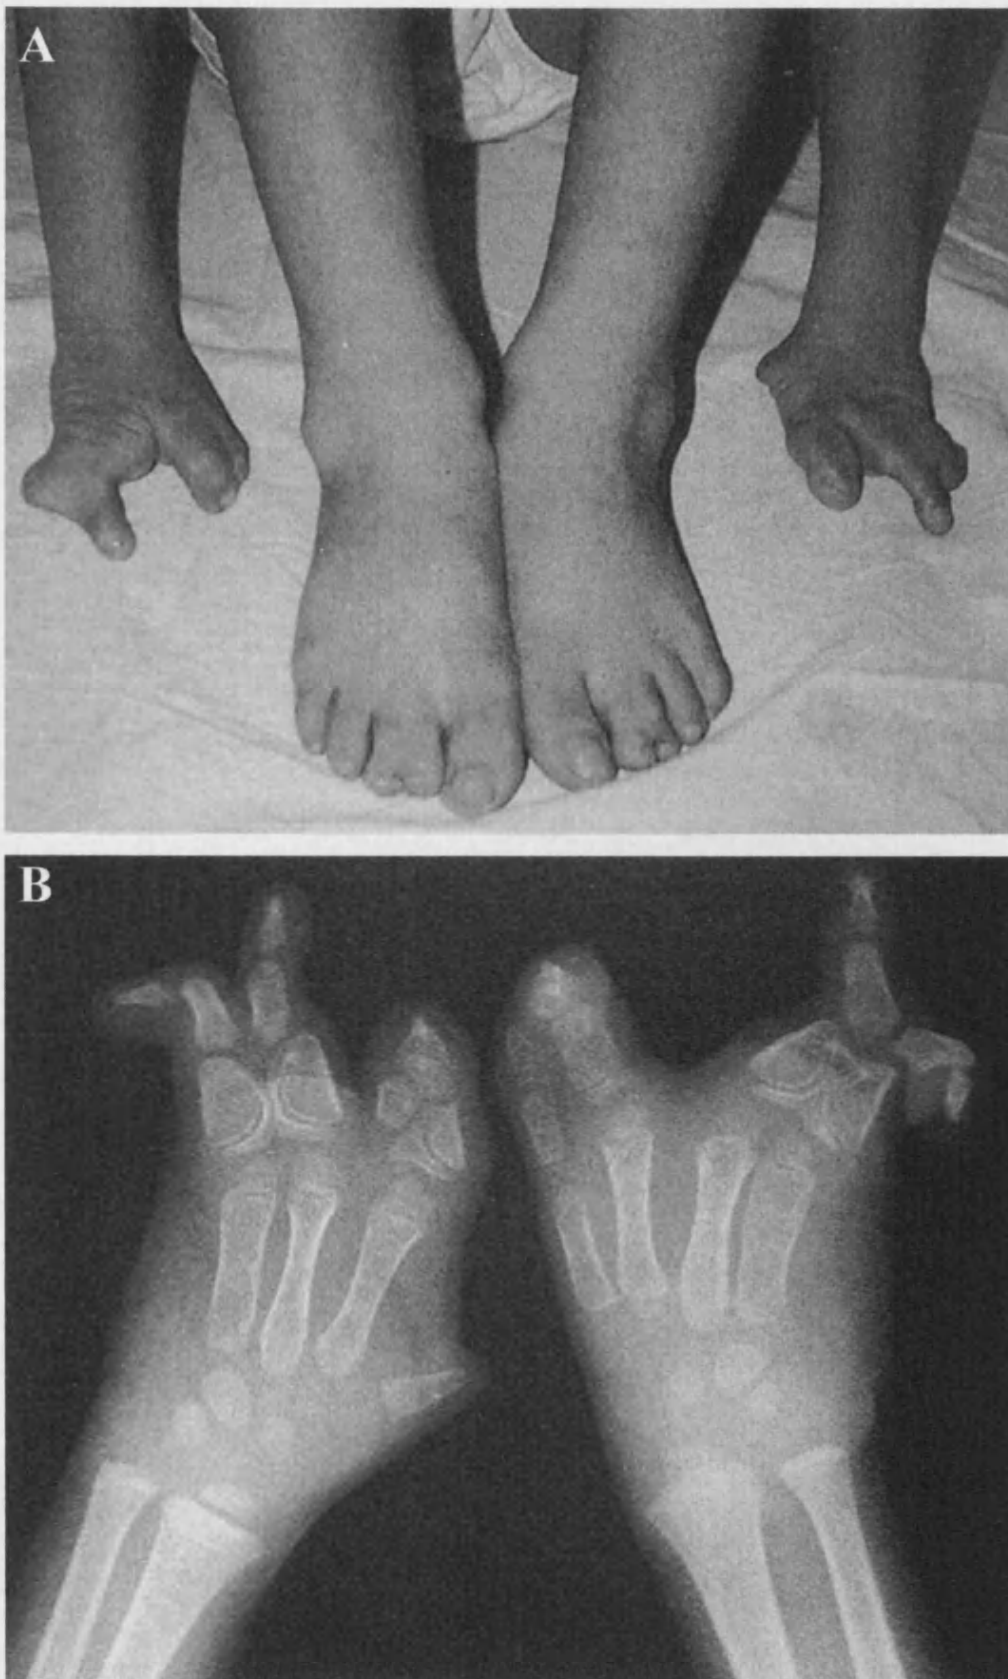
Clinical photograph and radiograph of the limbs of patient II.4 from Family B. In the hands, there is bilateral soft tissue syndactyly of all the digits, with shortening, fusion or absence of many of the phalanges and metacarpals (A and B). In the feet, there is bilateral syndactyly between the second and third toes. 107
